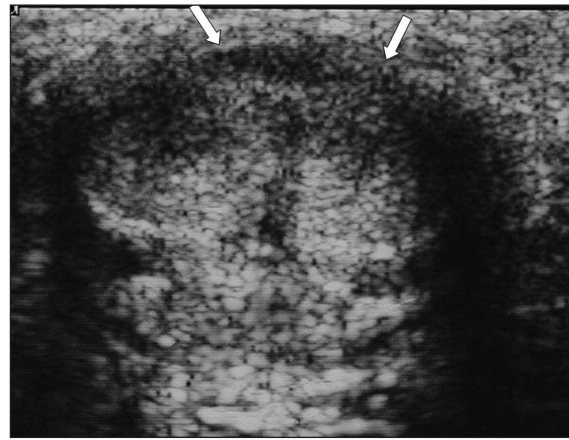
Less common variant of PD showing a hypoechoic well-defined nodular lesion of the tunica albuginea without acoustic attenuation or acoustic enhancement (arrows). The plaque is in the left lateral aspect of the penis. Right lateral access to the penile shaft is recommended. A, Longitudinal sonogram. B, Axial sonogram.
